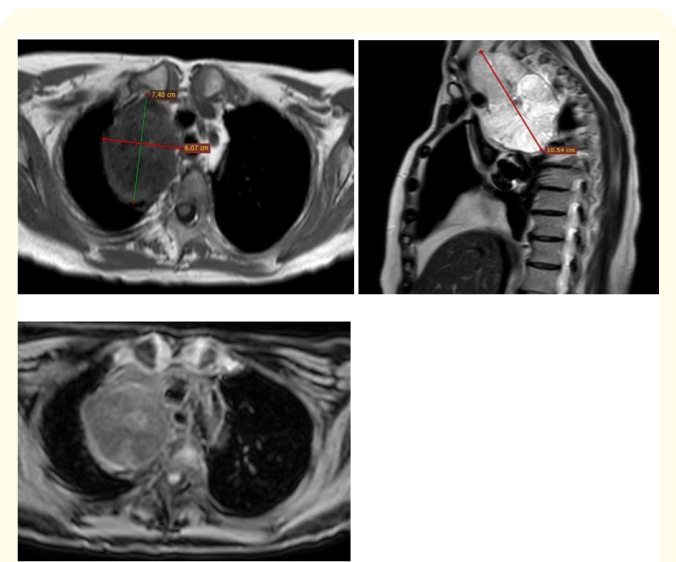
Axial T1-weighted, sagittal T2-weighted and axial T1 post-contrast images of the chest showing a 7.4 x 6 x 10.5 cm right superior mediastinal mass appearing predominantly hyperintense on T2 and hypointense on T1 with heterogeneous enhancement.
